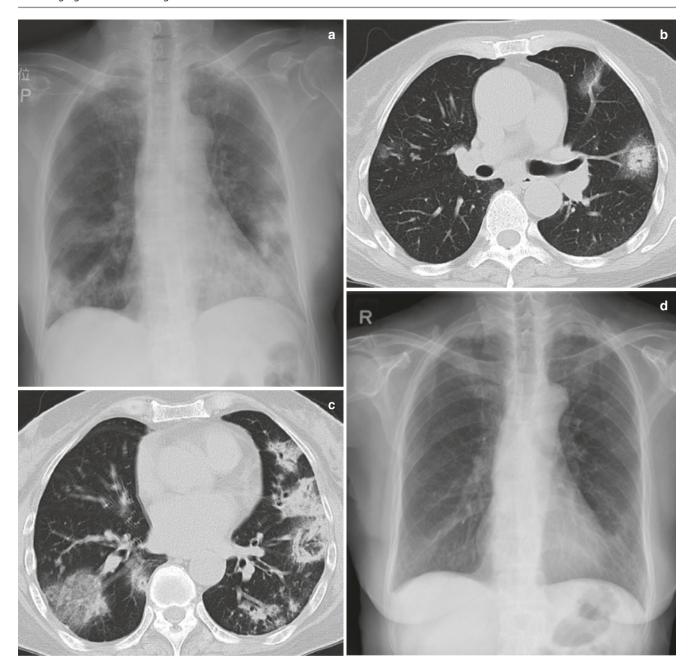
"Halo" and "reverse halo" sign in OP in an elderly woman from interstitial pneumonia with autoimmune features (IPAF). (a) Frontal chest radiograph at presentation shows multiple peripheral lower lung consolidations. (b, c) Axial CT images show multiple
